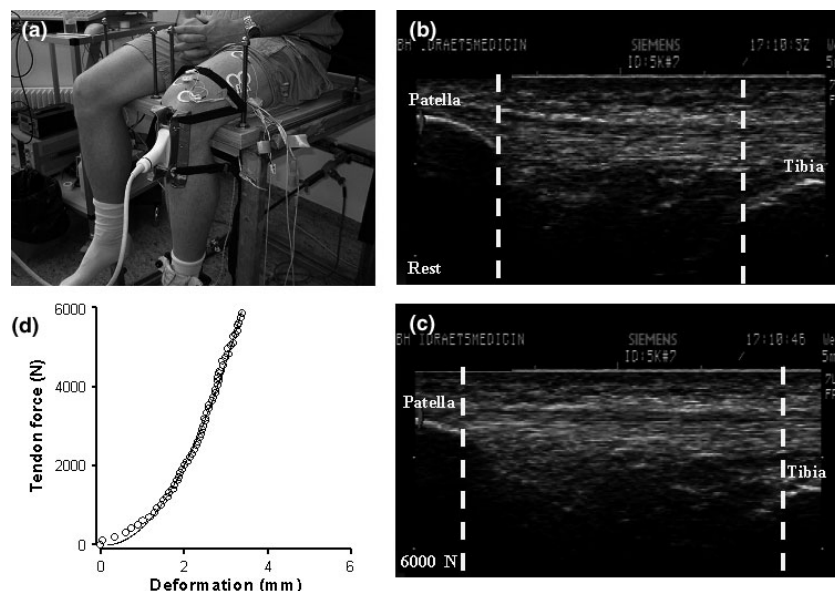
Measurement of patellar tendon mechanical properties. Subjects were seated in a custom-made rigid chair with hips and knees flexed to 90°, with a leg-cuff mounted to their lower leg and with the ultrasound-probe positioned in a way so that the patella and the tibia were both visible (a). Ultrasound video images were captured in order to measure displacement of the patella and tibia during force exertion (b & c). Synchronized values of patellar tendon force and tendon elongation/deformation was used to construct force-deformation curves from which the mechanical properties were subsequently calculated based on polynomial fitting (d).
